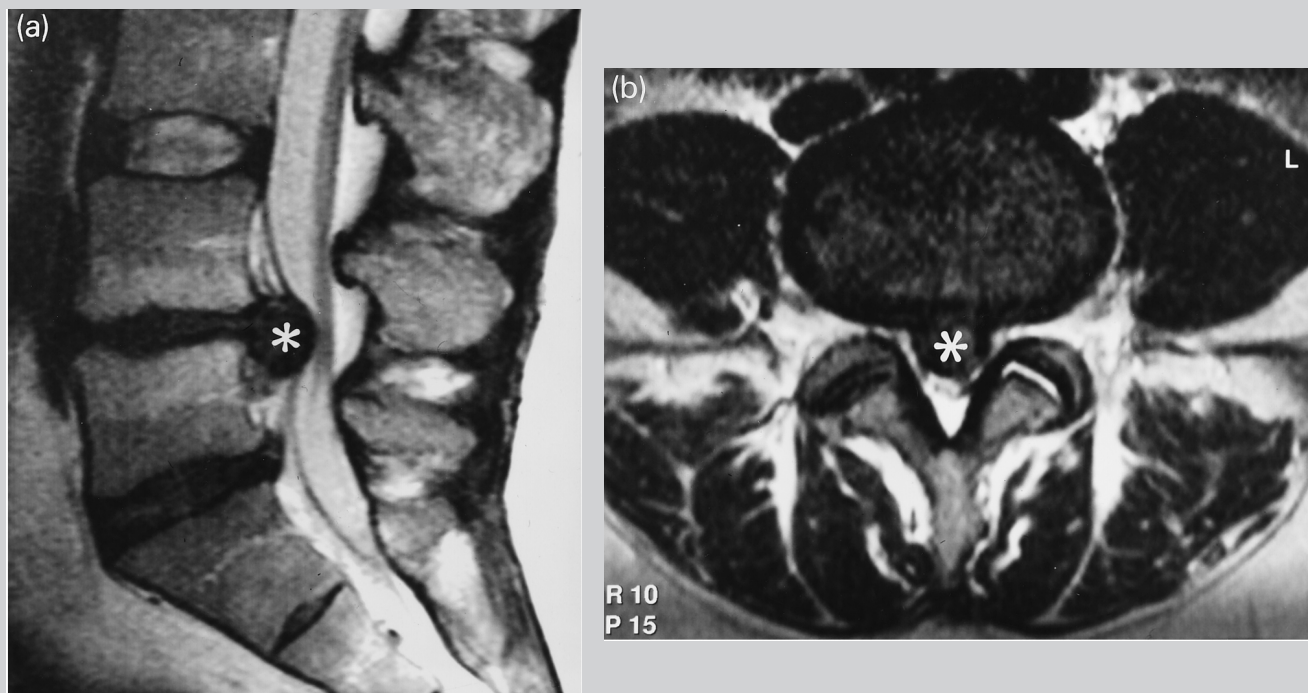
Sagittal (a) and axial (b) T2 weighted MR images of the lumbar spine to show a large central L4,5 disk extrusion (asterisks). The patient had an acute cauda equina syndrome.
